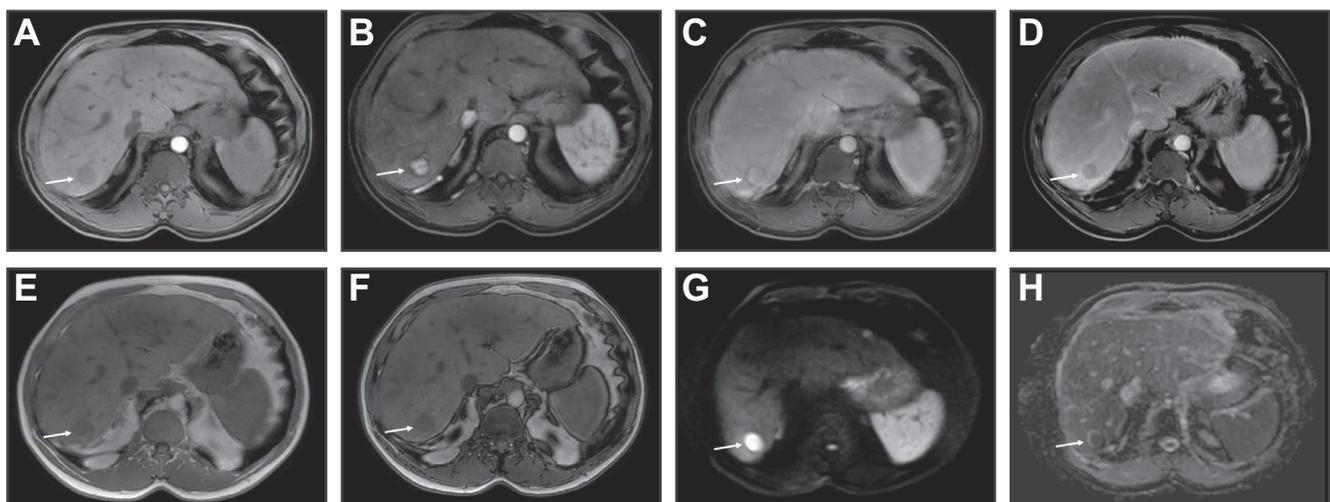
HCC in a 47-year-old man with primary Budd-Chiari syndrome of unknown cause. (A-C) Extracellular contrast-enhanced fat-suppressed T1-weighted GE MR images showed a hypointense lesion on precontrast T1-weighted images located in the right liver (A). The lesion showed (B) arterial phase hyperenhancement (arrow), (C) mild hyperintensity on portal venous phase and (D) washout appearance on delayed phase. (E) In- and (F) opposed-phase T1-weighted GE MR images show that the lesion did not contain fat. The lesion appears markedly hyperintense on (G) high b-value diffusion-weighted images with (H) low apparent diffusion coefficient values. The serum alpha-fetoprotein level was 402 ng/L. The patient underwent liver biopsy confirming the diagnosis of moderately differentiated HCC, which was treated by percutaneous radiofrequency ablation. HCC, hepatocellular carcinoma.
